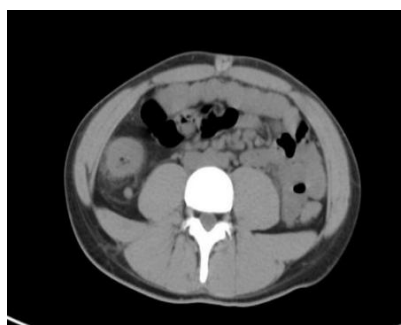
Plain CT scan of the abdomen and pelvis showed linear high density in the right iliac fossa, thickened and rough local tube wall in the ascending colon, and multiple small lymph nodes in the fat space around the ileocecal part
